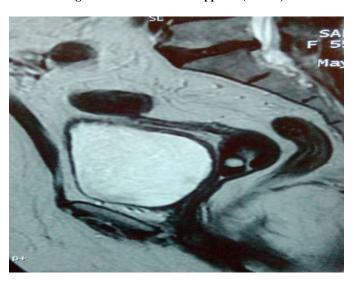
Post operative MRI shows no fistula tract
